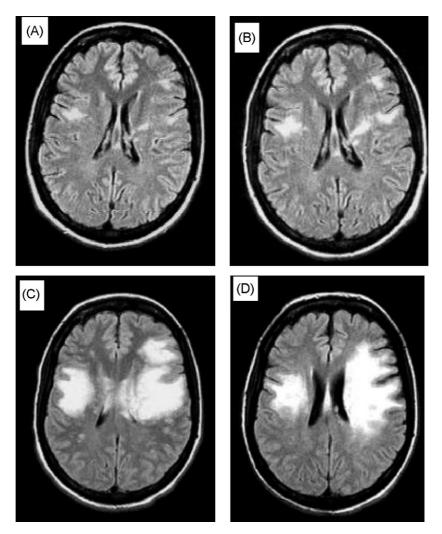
FLAIR MRI images on the axial plane passing through the atrium of the lateral ventricles at different dates. The images at neurological onset (panel A) and 15 days later (panel B) show focal alterations of the white matter surrounding the lateral ventricles, which had progressed extensively at the time risperidone treatment was started (panel C). One month after the end of such a treatment, improvement of the alteration and the compression on the ventricles are evident (panel D).
